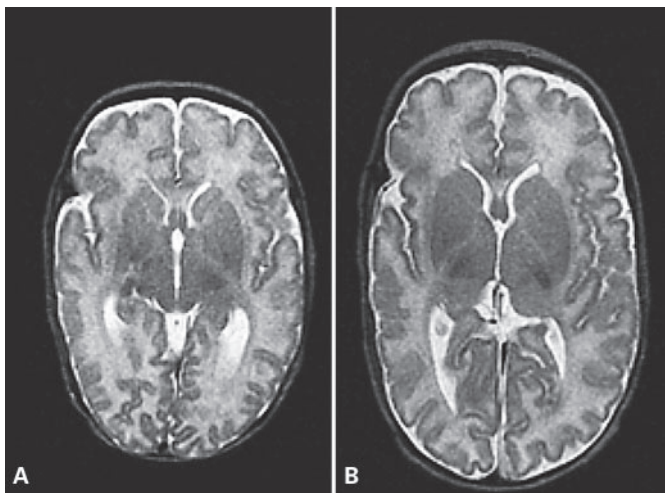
Axial T2-weighted magnetic resonance images from a premature infant at term treated with systemic dexamethasone for neonatal chronic lung disease (A), and a premature infant at term who never received dexamethasone (B). With permission from Murphy et al. [103].
